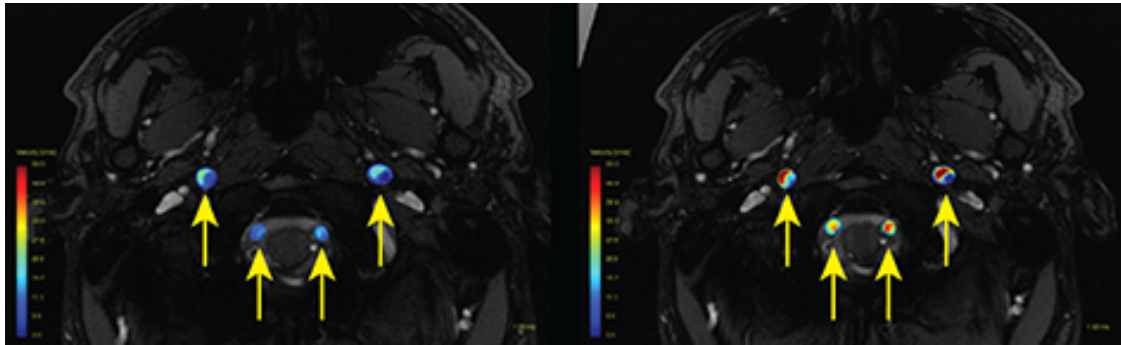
2D PC MRI images in a participant before (left) and after (right) acetazolamide administration. Vessels are pointed by the yellow arrows. The increase in velocity can be appreciated in all vessels depicted in colour. Color bar indicates velocity [ranging from 0 to 50 cm/s].
